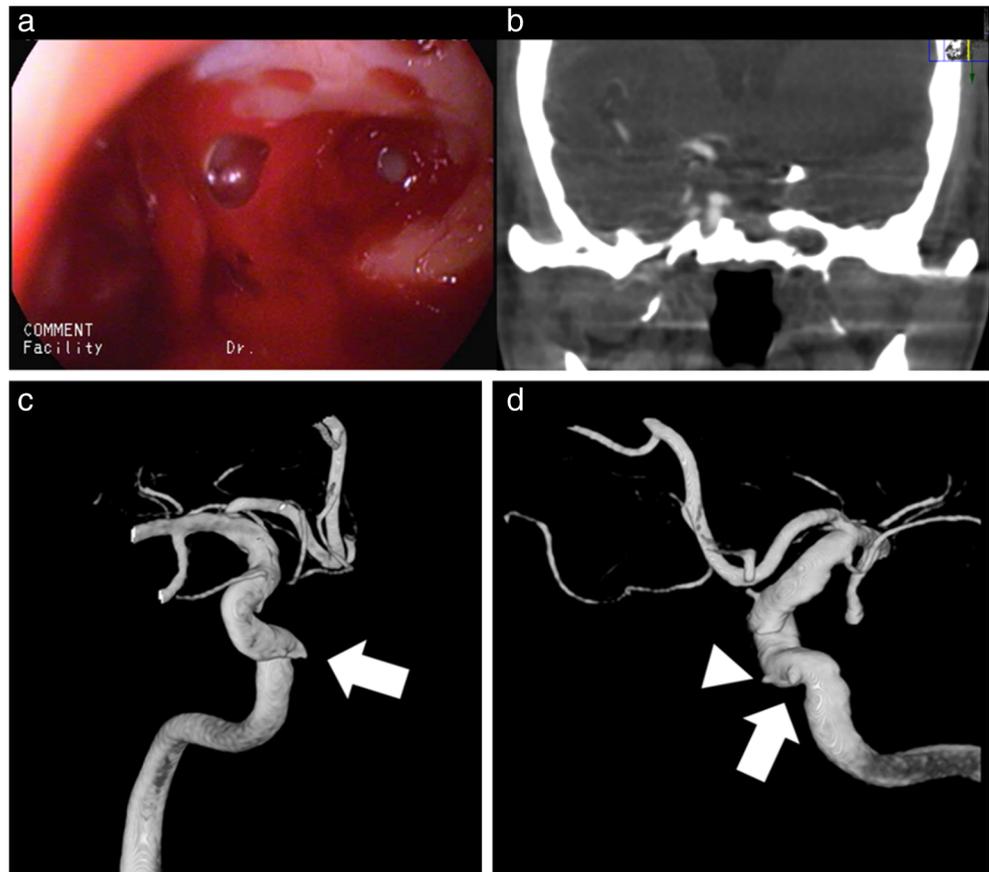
a Endoscopic examination showing pulsatile bleeding in the sphenoid sinus, which had been opened at the time of transsphenoidal surgery. b Cone-beam computed tomography image showing the aneurysm in the sphenoid sinus. c, d Three-dimensional digital subtraction angiography showing two aneurysms (5 mm (arrow) and 2 mm (triangle)). The aneurysms were located in the cavernous portion
